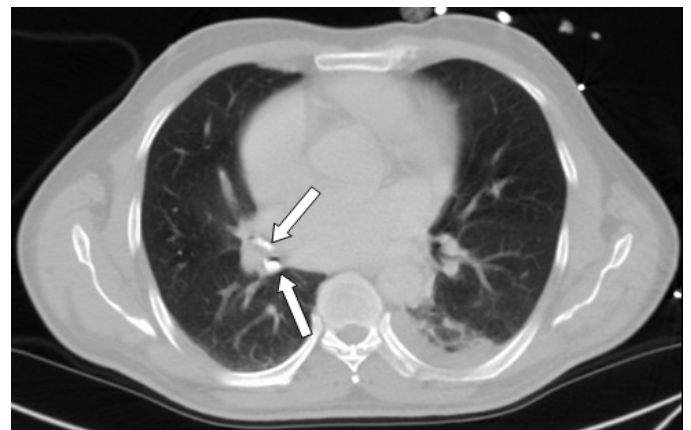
Inferior chest CT showing radiodense material within the right segmental bronchi (arrows).
